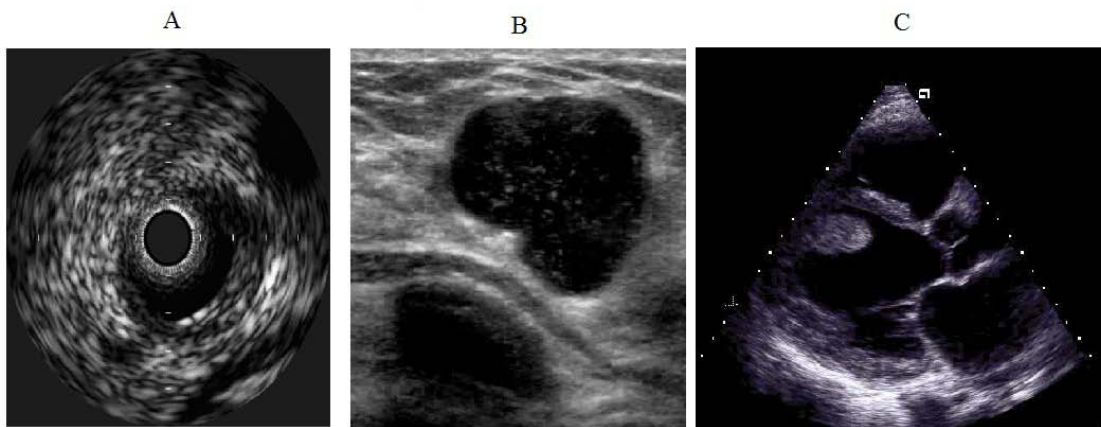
Clinical cross-sectional gray-scale ultrasound images for A: IVUS B: Linear image and C: Sector image.
